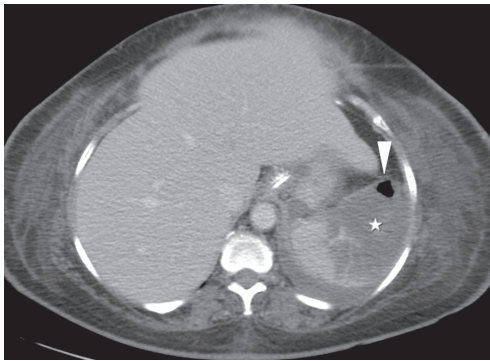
A 61-year-old woman with splenic infarction and signs of infection (abscess) complicating acute pancreatitis. Contrast-enhanced CT shows an area of splenic infarction (white star) with a gas bubble (arrowhead) as a sign of a splenic abscess.
